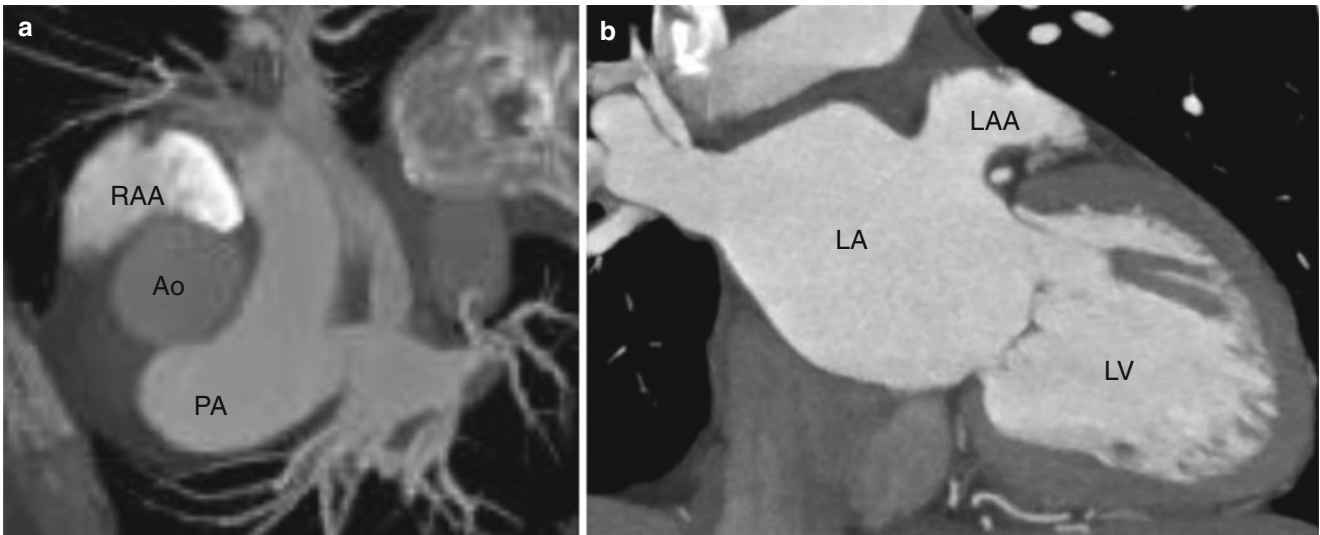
Computed tomographic (CT) examples of the right (panel a) and left (panel b) atrial appendages identifying the right and left atria, respectively. The right atrial appendage has a larger, broader connection to the right atrium, and the left atrial appendage has more trabeculations
